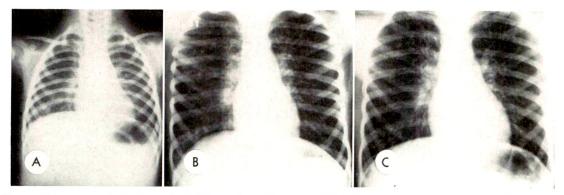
Roentgenograms of a male child at (A) 1, (B) 10 and (C) 12½ years. A was made at the time of adenoidectomy, performed for wheezing and cough which he had had since the age of 3 weeks. The boy was treated with continuous desensitization for asthma until the age of 8, when a sweat test revealed an elevated chloride level of 119 mEq./L. When aggressive respiratory management was initiated at the age of 10 (B) he was very small, below the third percentile in height and weight. Two and a half years later (C) he had gained weight, and the pulmonary infection was improved.
